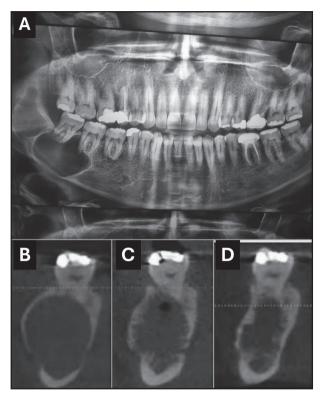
(A) Pre-operative Panoramic x-ray of one of the studied cases. (B, C and D) Pre-operative cross-sectional CBCT images.
